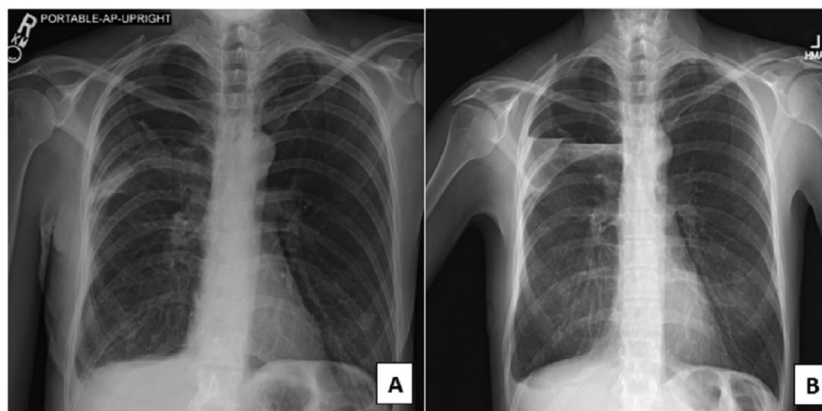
Chest X-ray after chest tube removal revealed stable small apical pneumothorax (A). Chest X-ray after 2 weeks revealed stable pneumothorax with obliteration of right costo-phrenic angle and loculated apical effusion likely due to the previous pleurodesis.
